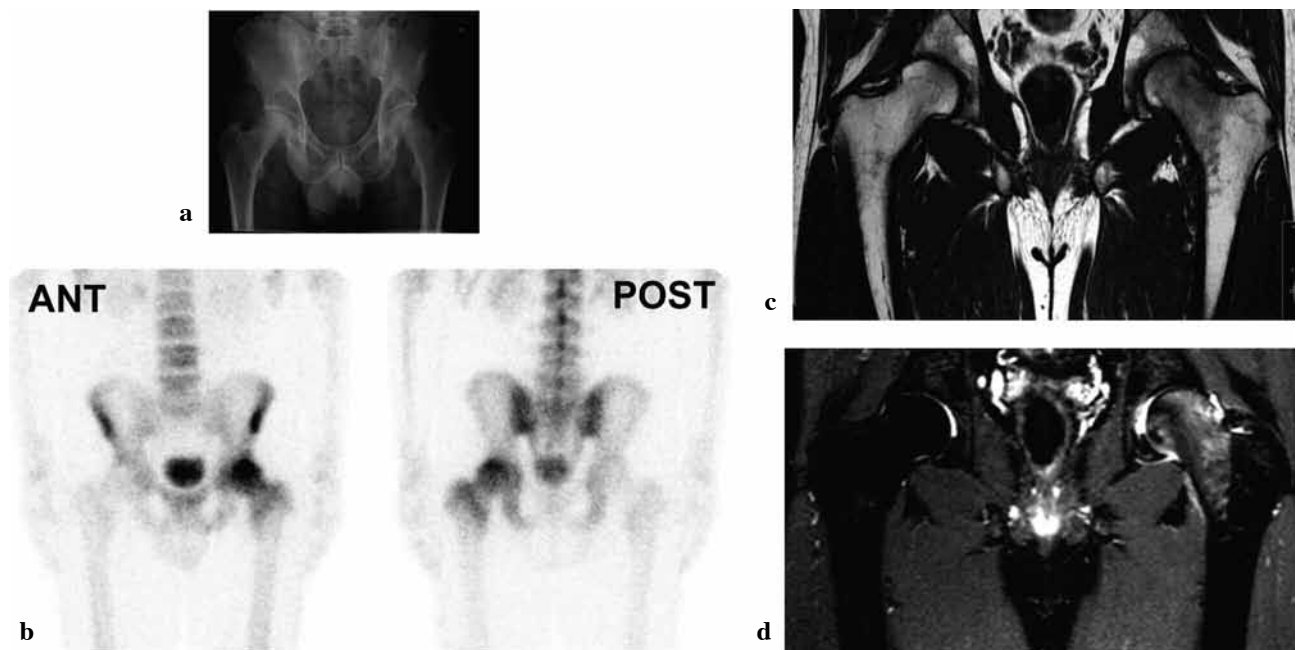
Case 2 : a : plain radiograph : no osteopenia left hip ; b : delayed planar bone scan : increased uptake left hip as far as intertrochanteric line ; c and d : T1-weighted and fat suppressed T2-weighted MRI : bone marrow edema as far as the intertrochanteric line ; hip joint effusion.
